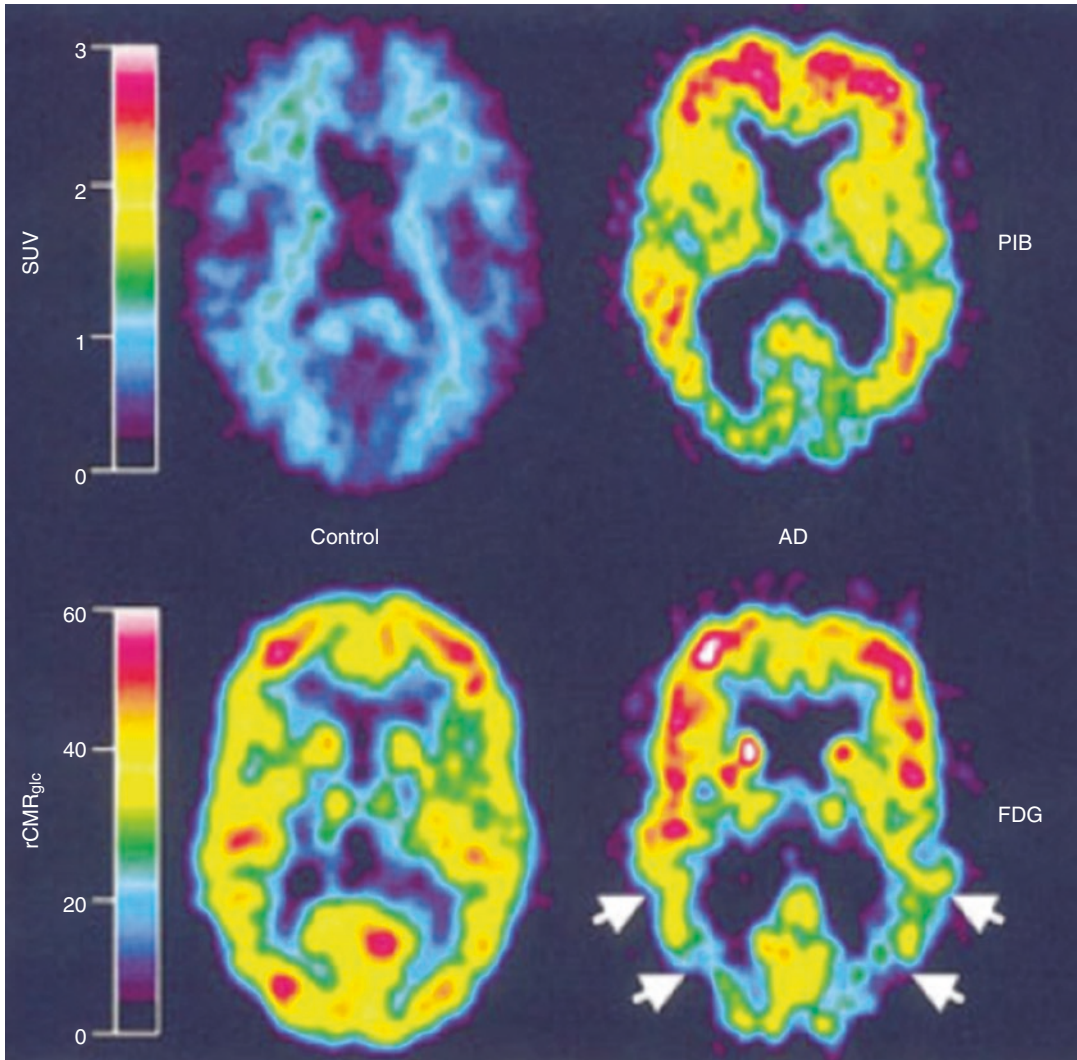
PIB standardized uptake value (SUV) images demonstrate a marked difference between PIB retention in Alzheimer's disease (AD) patients and healthy control (HC) subjects. PET images of a 67-year-old HC subject (*left*) and a 79-year-old AD patient (AD6; MMSE _ 21; *right*). (*top*) SUV PIB images summed over 40–60 min; (*bottom*) ¹⁸F-DOPA rCMR_{glc} images $\mu\text{mol}/\text{min}/100 \text{ ml}$. The left column shows lack of PIB retention in the entire gray matter of the HC subject (*top left*) and normal ¹⁸F-DOPA
